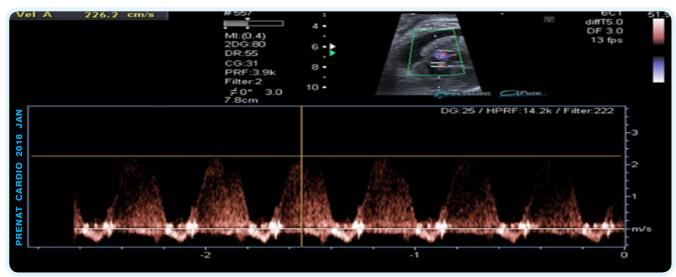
Tricuspid regurgitation of 226 cm/s in 330/7 weeks gestational age assessed by Puls-wave Doppler
